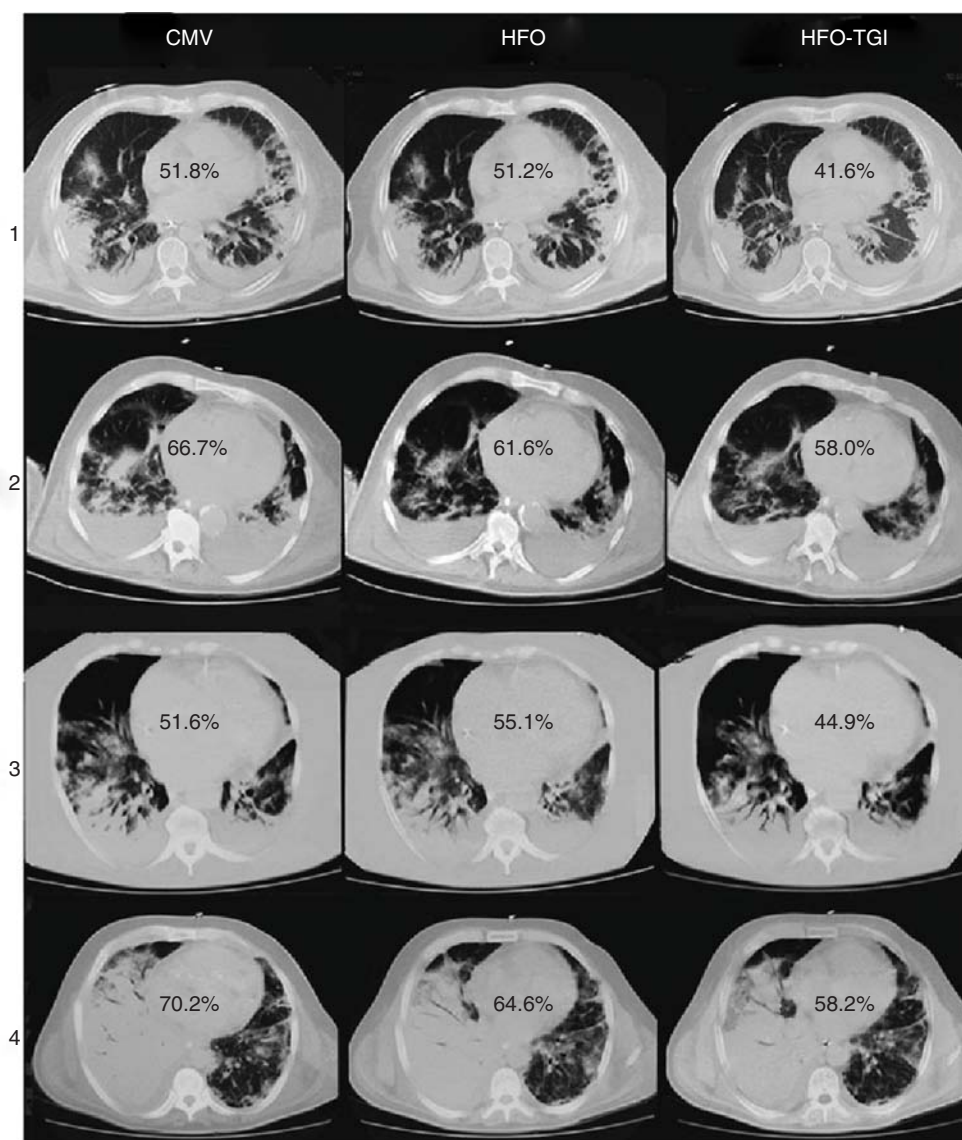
Computed tomography (CT) sections of the lower lung from four representative patients (1 to 4). CT sections correspond to 7 cm below the carina. In patients 1 and 3, HFO preceded HFO-TGI. In patients 2 and 4, HFO-TGI preceded HFO. Percentages reflect proportions of nonaerated lung-tissue weight in lower-lung CT sections. Regional gas volume was higher during HFO-TGI versus CMV and HFO. In the nondependent lower lung, there was a HFO-TGI-related decrease in the percentage of nonaerated parenchyma versus CMV and HFO. The corresponding regional lung volume and tissue weight were higher during HFO-TGI versus CMV and HFO; HFO-TGI resulted in a higher gas volume versus CMV, and a trend toward higher gas volume versus HFO. *CMV*, conventional mechanical ventilation; *HFO*, high-frequency oscillation; *TGI*, tracheal gas insufflation. (Used, with permission, from Mentzelopoulos SD, Theodoridou M, Malachias S, et al. Scanographic comparison of high frequency oscillation with versus without tracheal gas insufflation in acute respiratory distress syndrome. *Intensive Care Med.* 2011;37:990–999.)
